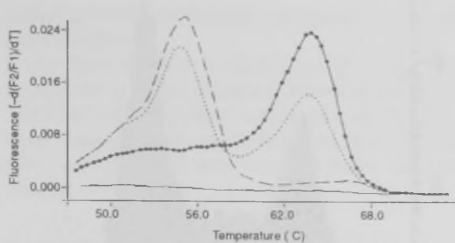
Genotyping of the C3435T exon 26 polymorphism of the MDR1 gene on the LightCyclerTM. The homozygous TT sample (—), heterozygous CT (- - -), and the homozygous wild-type CC sample (-•-•-).
